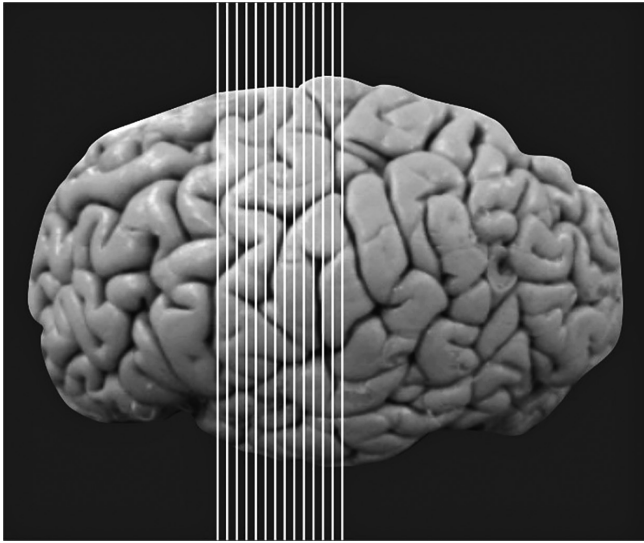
Obtaining TSE (T1 FLAIR) images with a section thickness of 2 mm by skipping 1 cm by segmentation method on coronal plane MRI. FLAIR, fluid-attenuated inversion recovery; MRI, magnetic resonance imaging; TSE, turbo spin echo.
